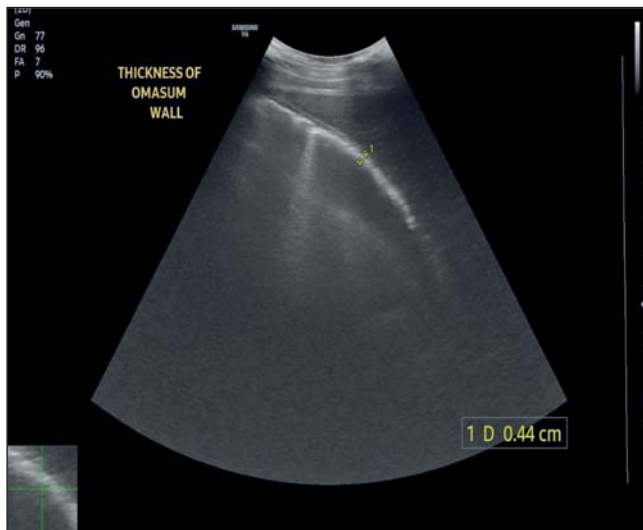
Ultrasonographic measurement of the thickness of omasal wall.
